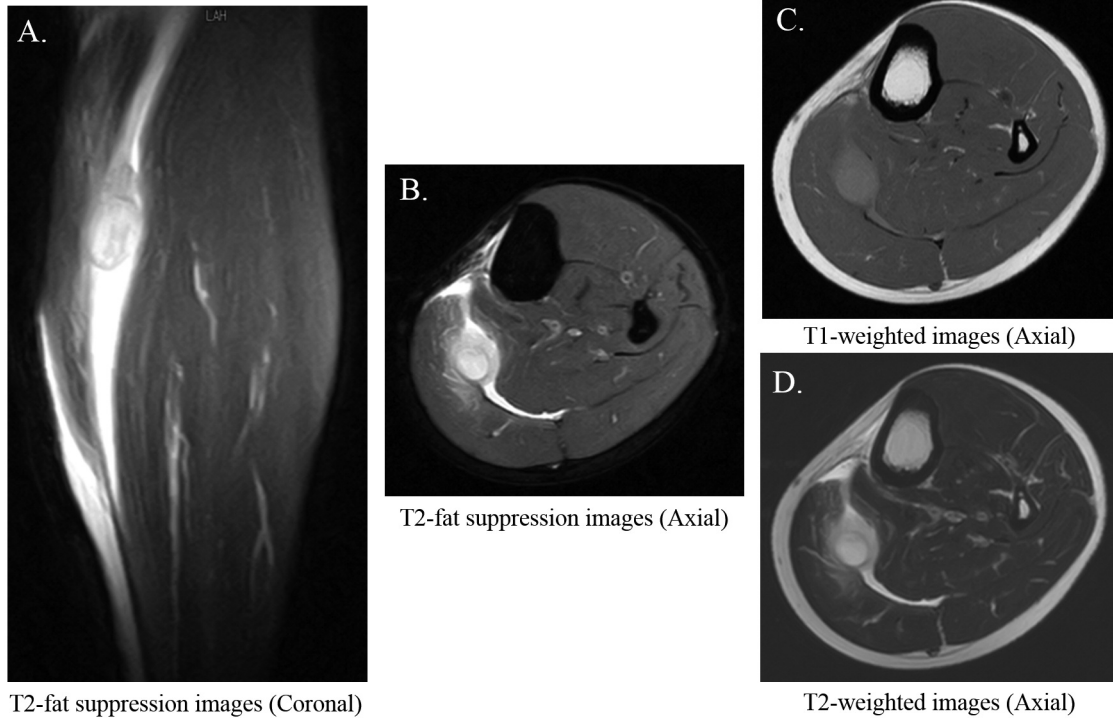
A coronal view (A) and axial view (B) of T2-fat suppression magnetic resonance (MR) images. An axial view of T1-weighted MR images (C). An axial view of T2-weighted MR images (D).
